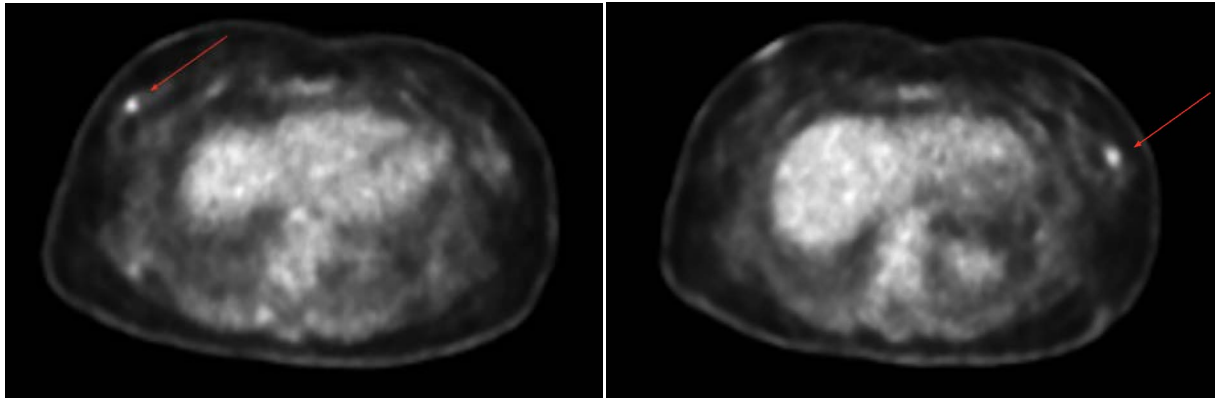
PET/CT images of FDG-avid bilateral breast nodules as indicated by red arrows.
